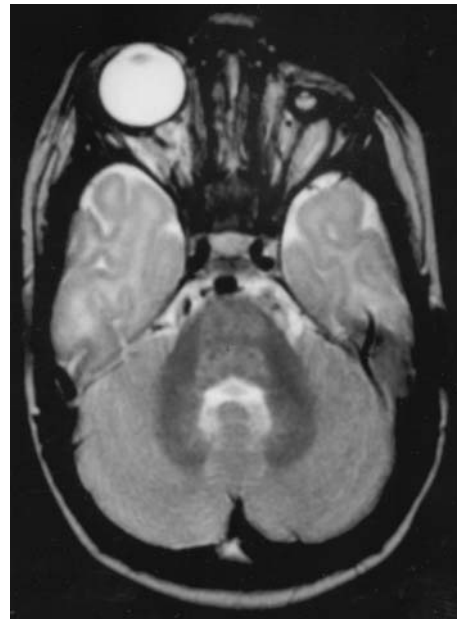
T2/FSE axial magnetic resonance image (MRI) of a 5-month-old girl with unilateral anophthalmos (clinically). MRI shows normal orbital anatomy and normal brain
